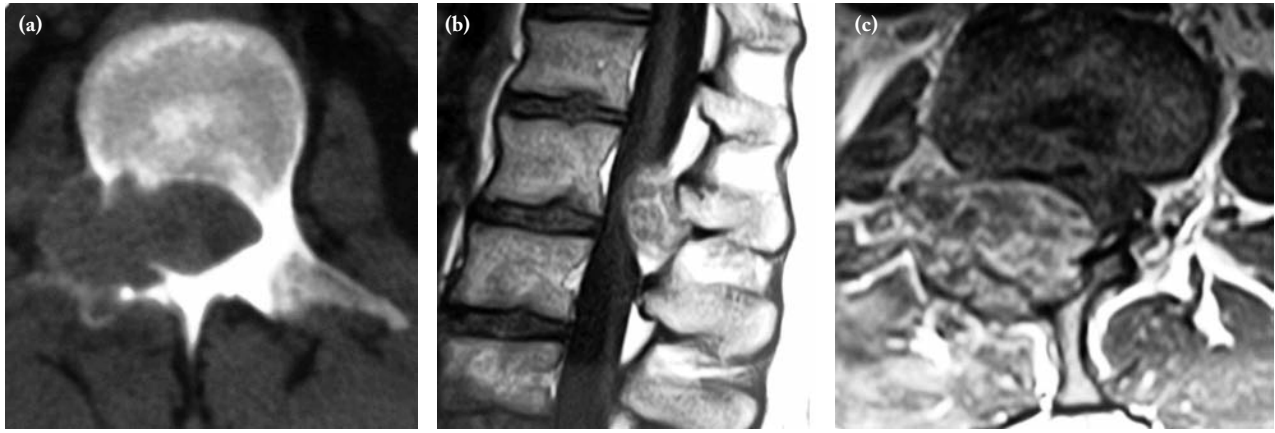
a. Damage of cortex inside canal by tumor tissue invading lamina and pedicle in CT, b. Compression of spinal cord by tumoral tissue in sagittal MRI. c. Involvement of L1 vertebra right pedicle, transverse projection, facet joint and lamina in axial MRI section.
